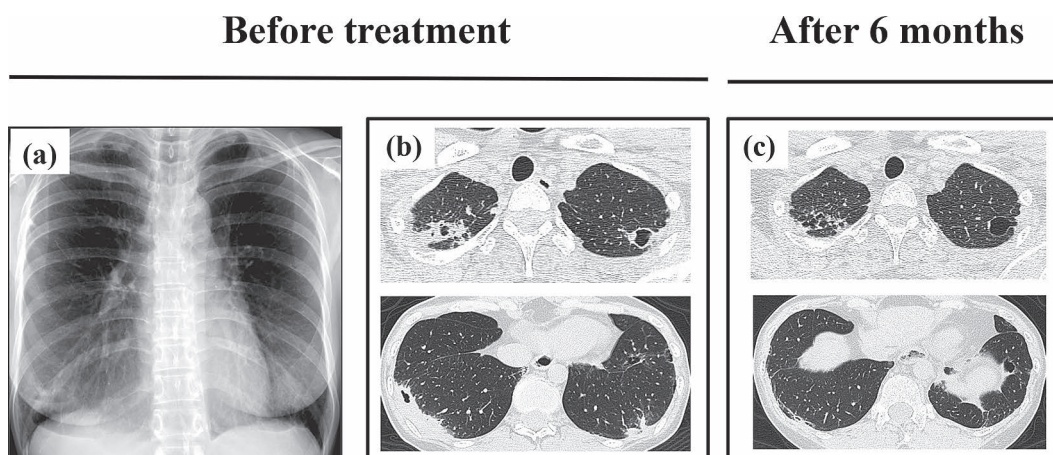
Chest X-ray and high-resolution computed tomography.
